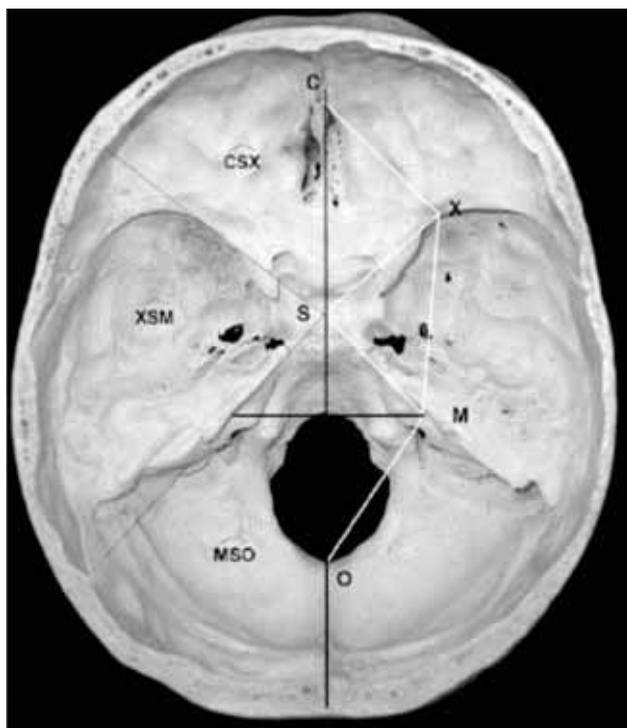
CBCT cranial base measurements
